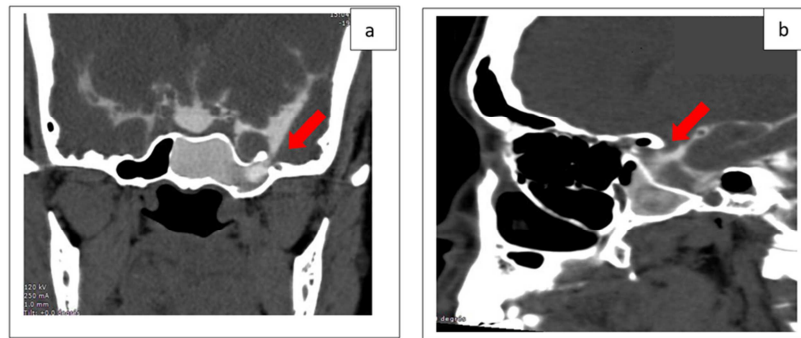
Cistern CT scan in coronal (a) and sagittal (b) reconstruction showing a lateralized fracture to the left of the upper wall of the sphenoid sinus allowing the contrast product to leak into the said sinus indicating the existence of an osteomeningeal breach.
